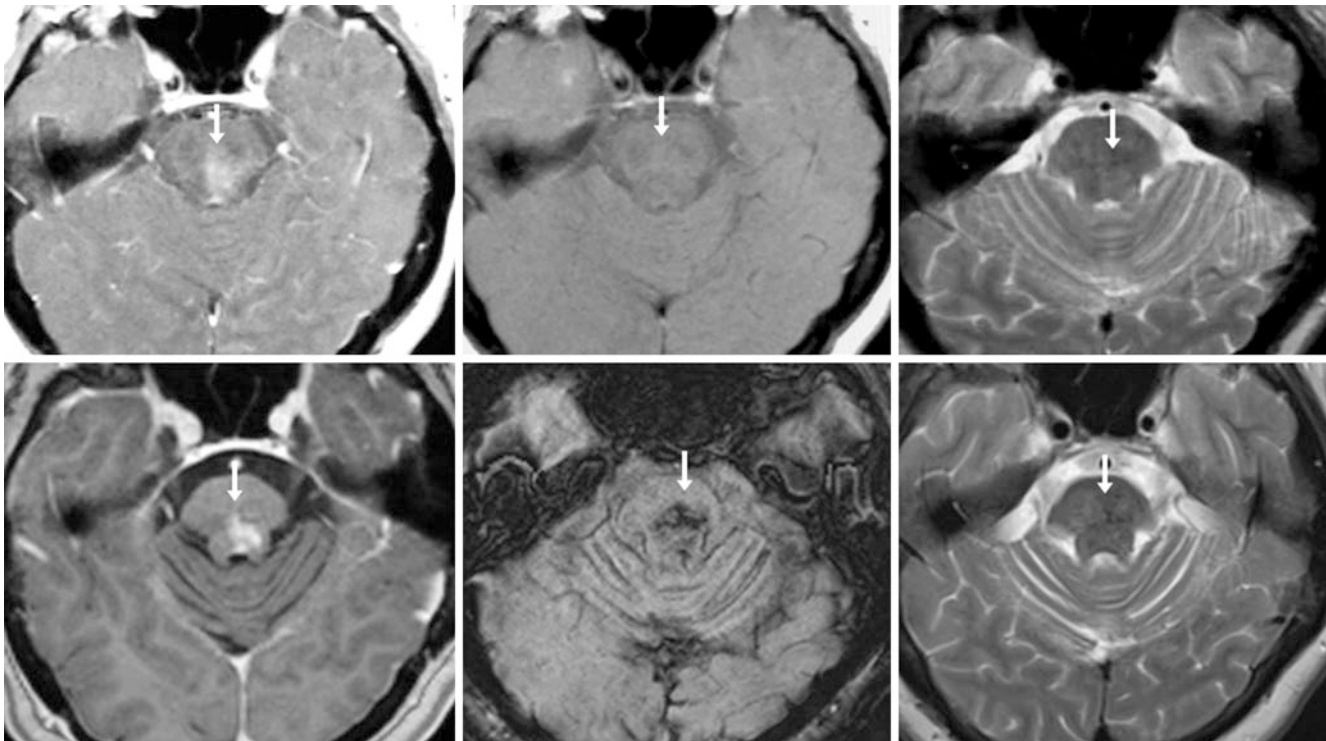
Large pontine BCT in a 58 year old with ataxia. On a 1.5T brain MRI, postcontrast SE T1WI (top left) depicted rather avid enhancement, whereas precontrast T1WI (top middle) and T2WI (top right) were unremarkable. On a 1.5T MRI obtained 15 years later, post-contrast GE T1WI (bottom left) shows that the BCT is more discrete, while SWI (right middle) shows a darker signal than is typically seen within a BCT. The T2WI (bottom right) is unchanged
